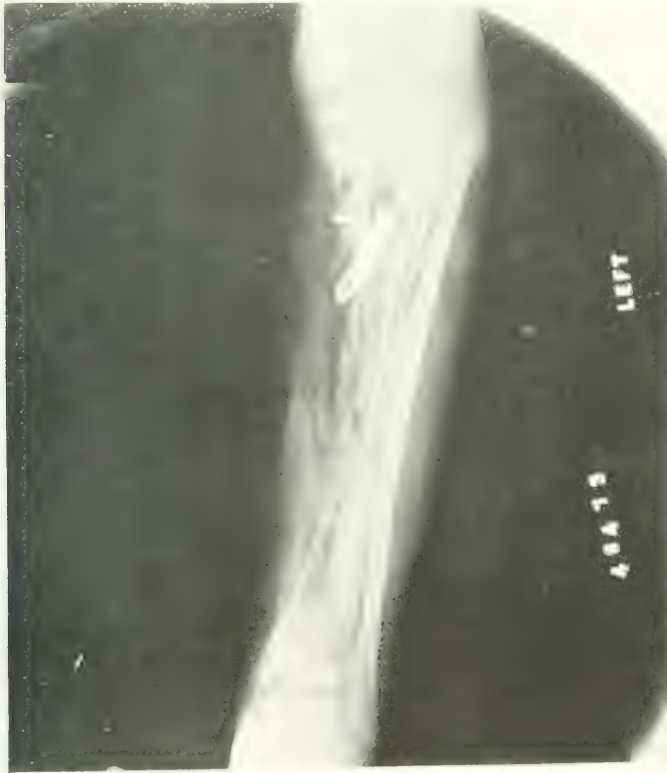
Clinical case No. 10. X-ray February 7, 1920. Operation December 9, 1919. Anterior surface of the cortex of the tibia removed. Drainage tube in popliteal space shown. See case history.
